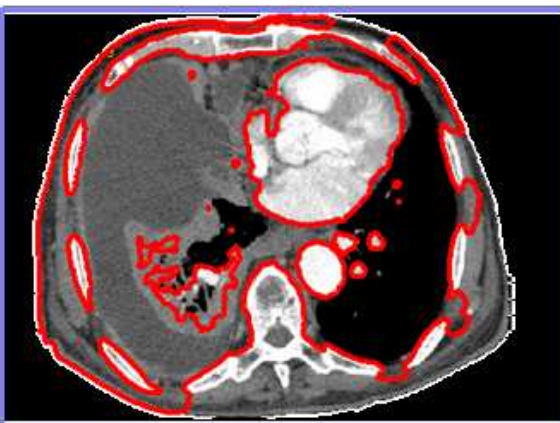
CT of patient (P_2) with Caselle segmentation algorithm [10] to highlight cancerous tissues, at advanced stage. Pleural effusion associated with nodular lymphadenitis. The figure shows the contour of the pleural effusion with red colour.
